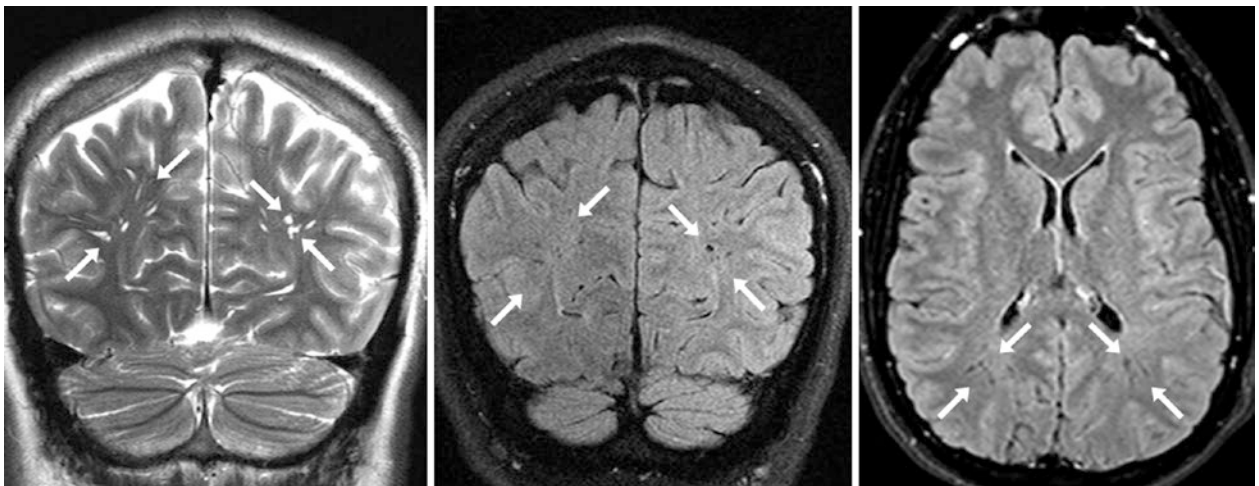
A 24 year old had PVSs of the parieto-occipital white matter bilaterally (*between arrows*) on a 3T MRI. The PVSs are radiating ovoid foci on coronal T2WI (*left*) that suppress on coronal (*middle*) and axial (*right*) FLAIR images
